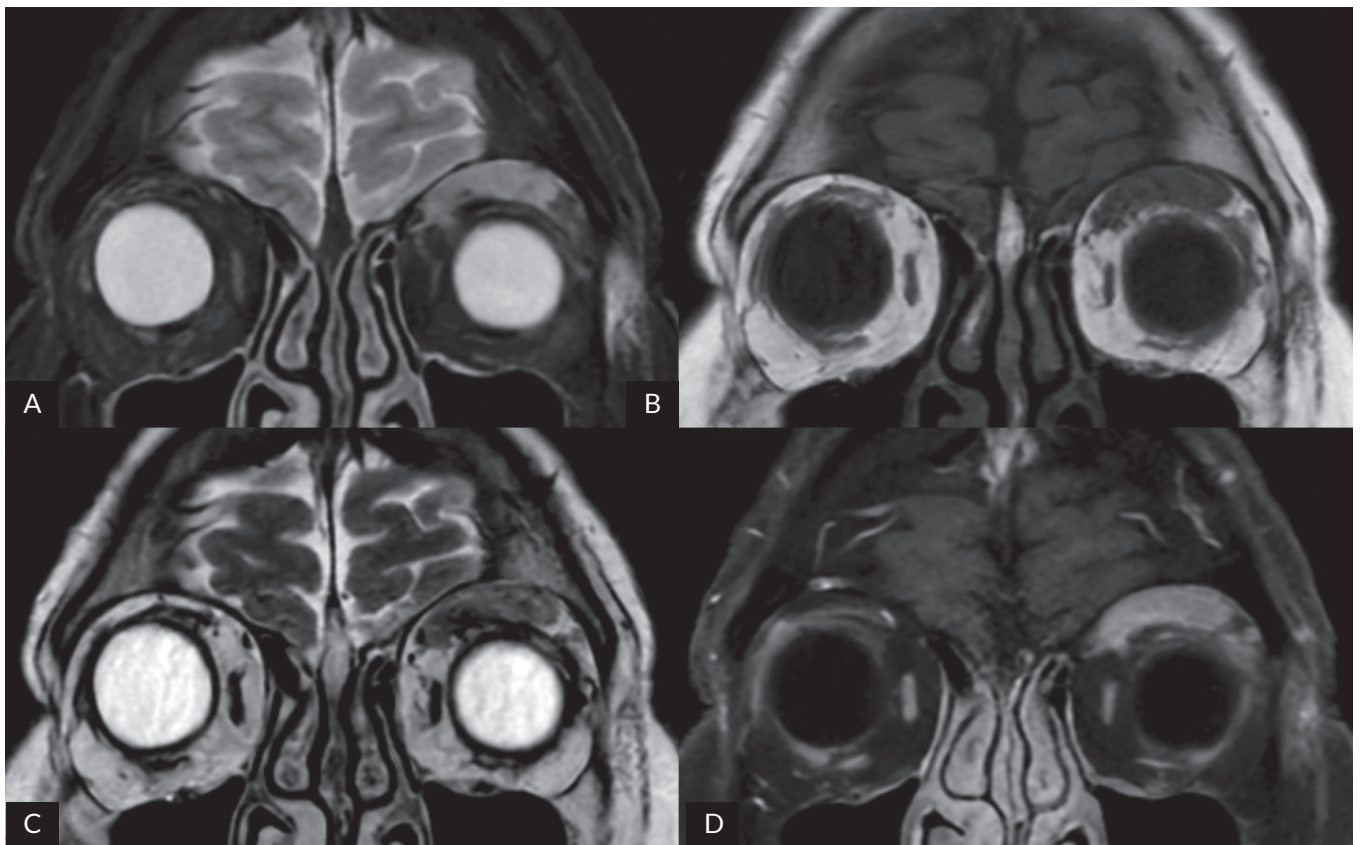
Selected coronal MRI scans of the orbits demonstrate a lymphoma at the roof of the left orbit. A. STIR image. B. Pre-contrast T1-weighted image without fat suppression. C. T2-weighted image. D. Post-contrast T1-weighted image with fat suppression
